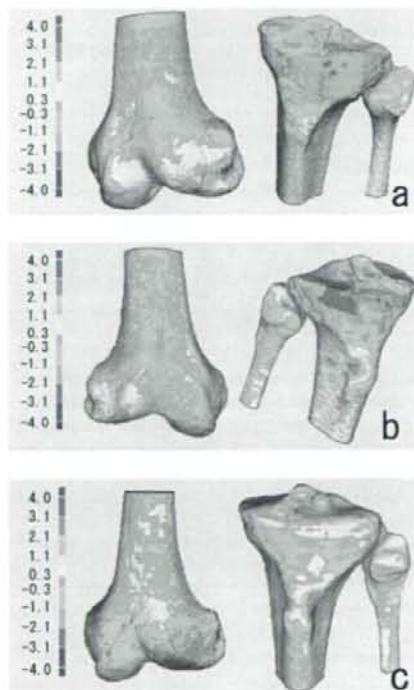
Three-dimensional distance measurement from CT model to MRI model (mm). (a) Subject 1, (b) subject 2, and (c) subject 3.
